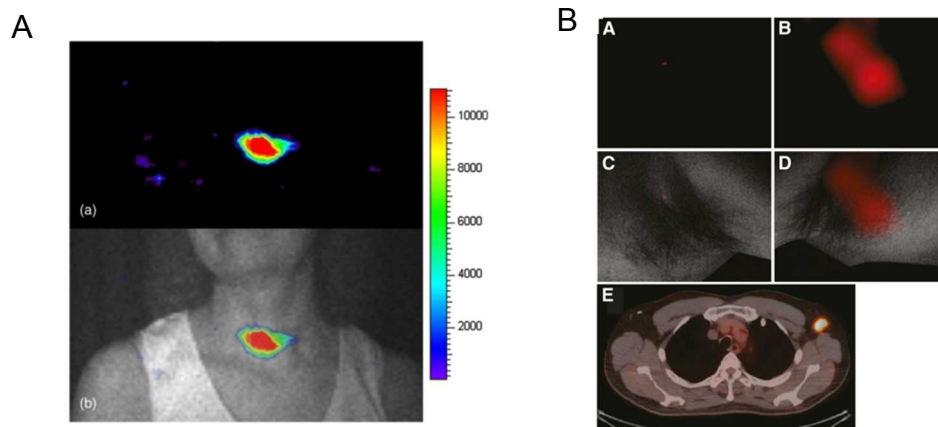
Clinical Cerenkov imaging. *A.* First human Cerenkography of patient with hyperthyroidism treated with ^{131}I . Adapted from (Spinelli et al., 2013). *B.* Cerenkov imaging of axillary lymph node malignancy in a patient with lymphoma treated with ^{18}F -FDG. Adapted from (Thorek, Riedl et al. 2014).
